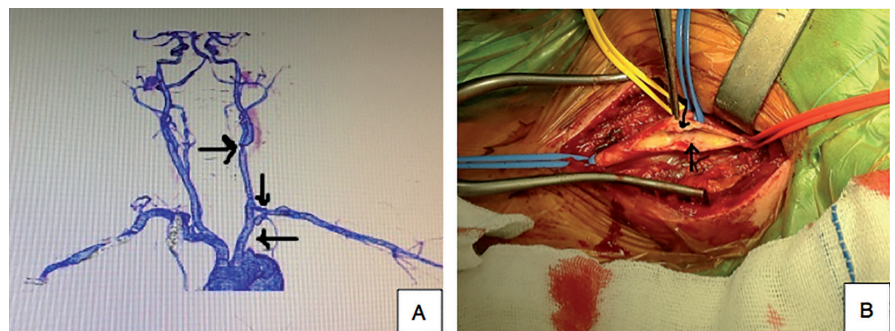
CTA view of the left common carotid artery occlusion just proximal to bifurcation (white arrow) (A). Operative view: Body of the bifurcated Dacron graft (14x8 mm) anastomosed to ascending aorta and its legs to bilateral common carotid arteries (B). End to side anastomosis to the right common carotid artery (C). Fresh thrombus inside the left common carotid artery (arrow) (D). End to end anastomosis to the left common carotid artery (E).
